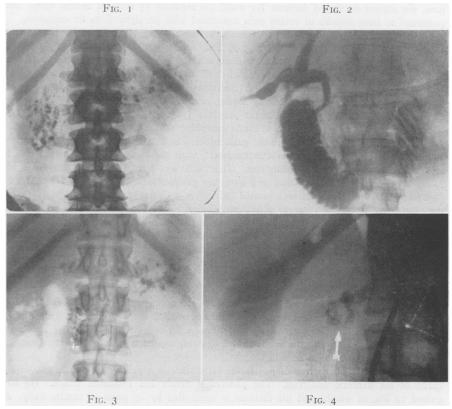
(Case 1) Preoperative roentgenogram showing widespread calcification of the pancreas.
